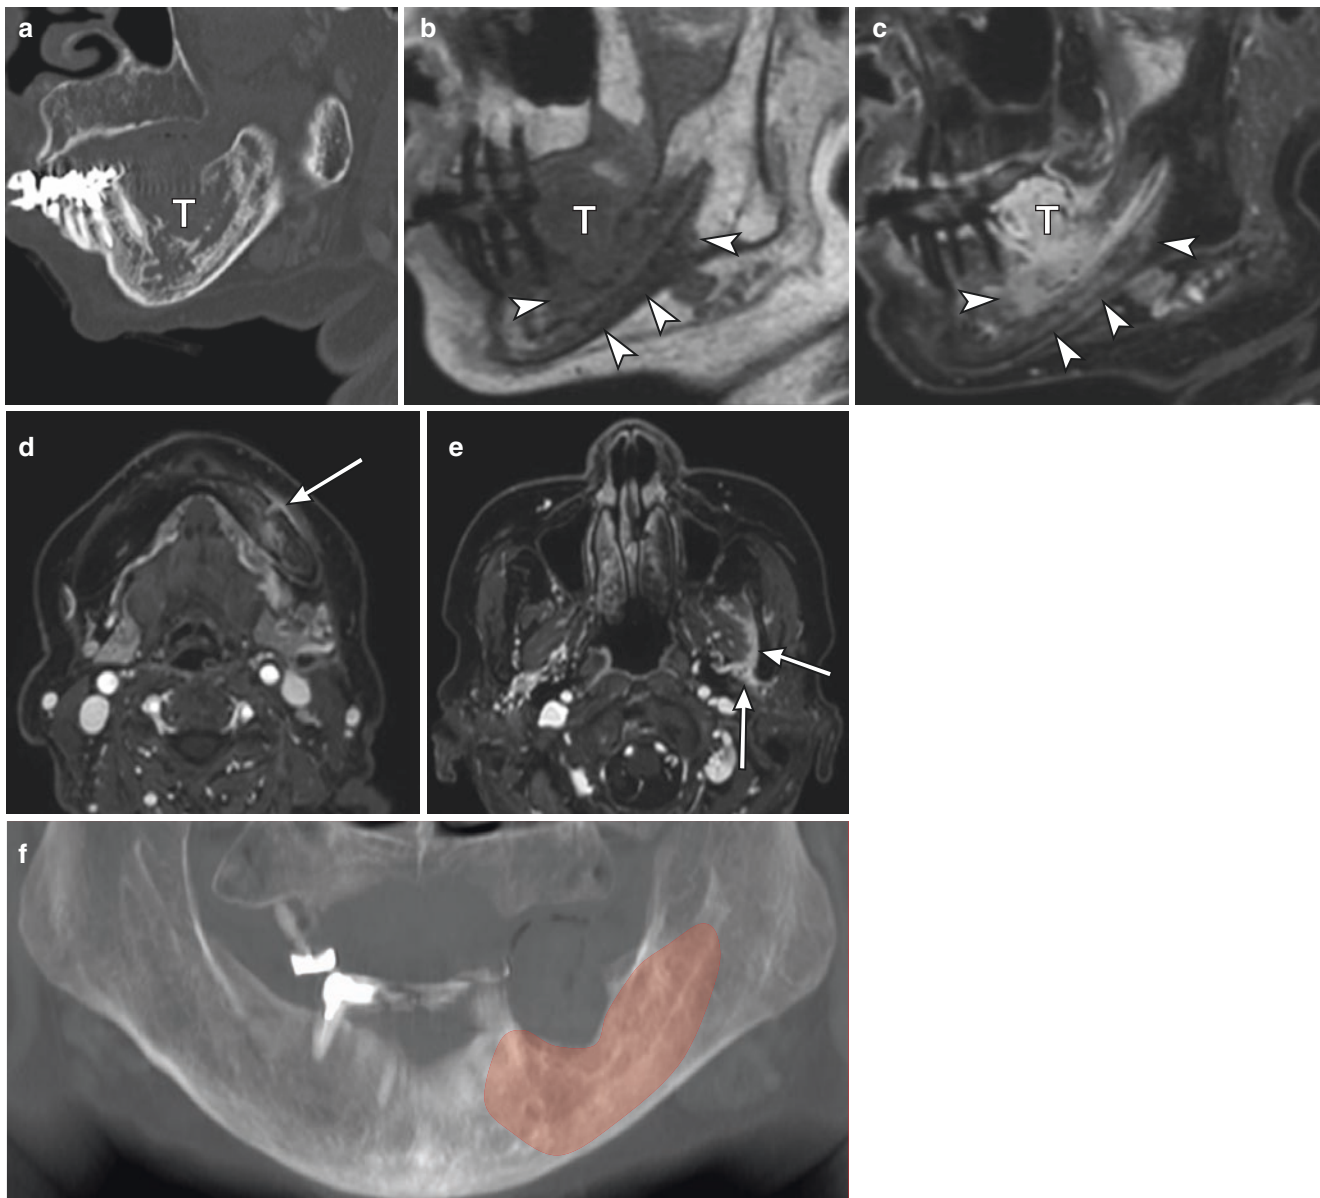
A 74-year-old woman with squamous cell carcinoma of the lower gingiva. (a) CT shows bone destruction by the tumor (T), but the extension of tumor could not be assessed. (b, c) Lower gingival cancer located at molar lesion invades into the bone marrow, which shows low signal intensity on the T1-weighted image (b) and post-contrast T1-weighted image with fat suppression (c). Range of tumor extension
